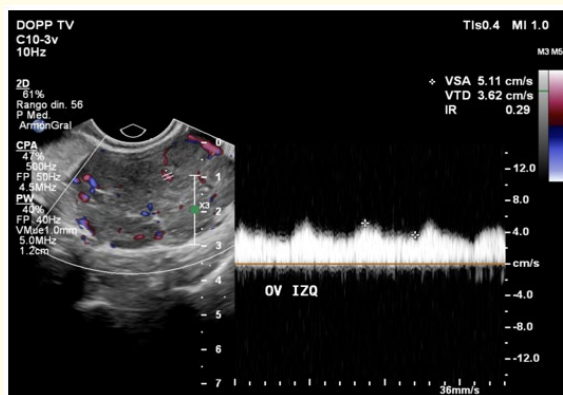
Doppler ultrasound shows a solid heterogeneous left ovarian mass with low RI.
